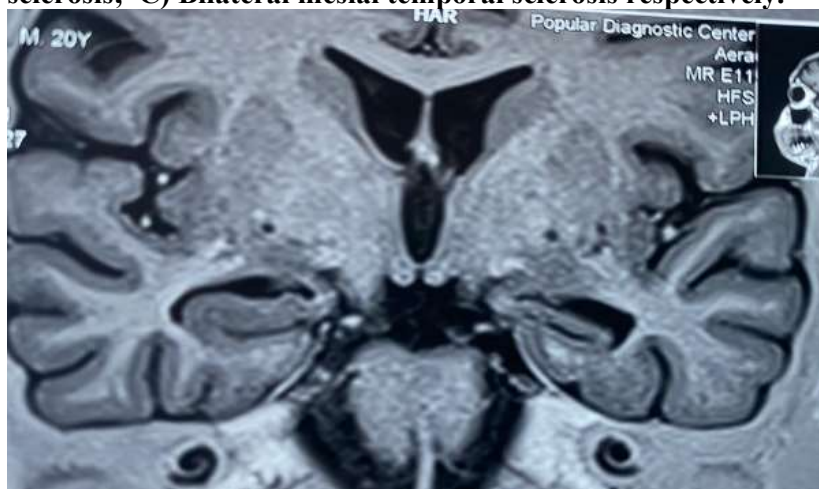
Coronal fluid-attenuated inversion-recovery (FLAIR) image of MRI with epilepsy protocol showing bilateral hippocampal atrophy.
